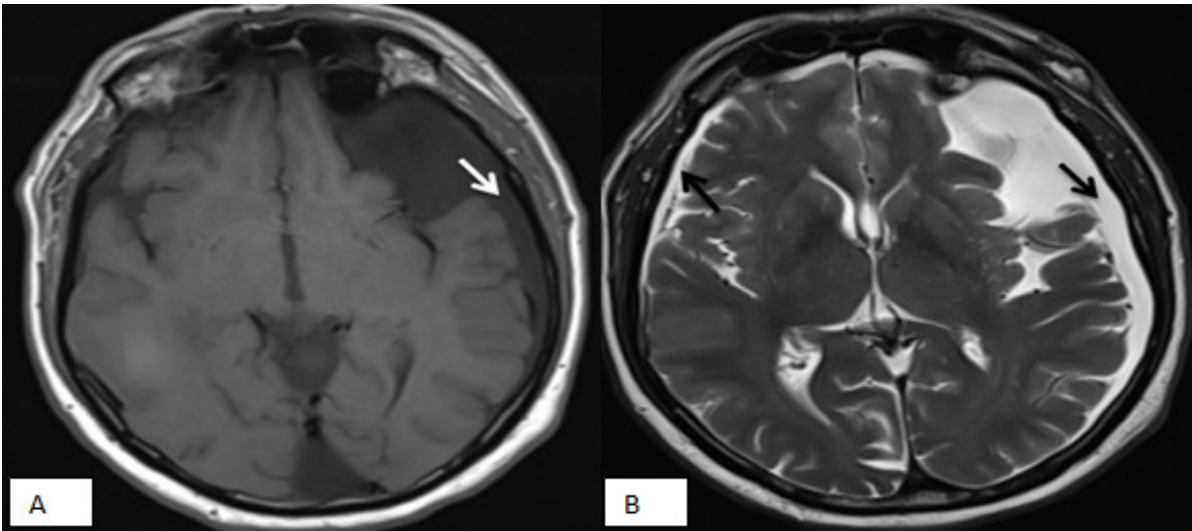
MRI shows the SDF collections having homogeneously same signal intensities with the CSF on T1w (A, white arrow) and T2w (B, black arrow) images
